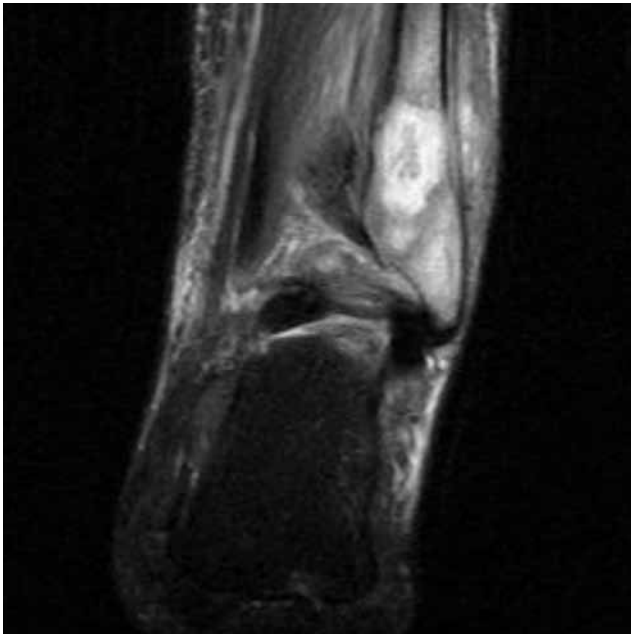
Coronal magnetic resonance imaging shows signal abnormality in distal fibula with linear density consistent with pathologic fracture.
